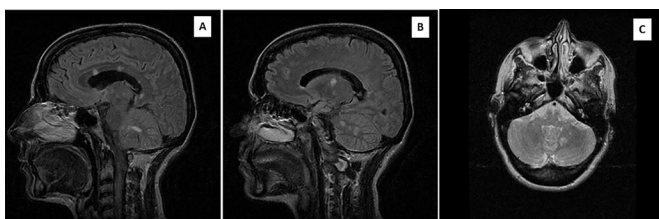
Fluid-attenuated inversion recovery (FLAIR) MRI at presentation. (A) FLAIR sagittal MRI showing white matter lesions in the corpus callosum (snowball lesions) and cerebellum lesion. (B) FLAIR sagittal MRI which shows the extension of the cerebellum lesion and the affection of the basal ganglia. (C) FLAIR axial MRI with a new view of the cerebellum lesion.
